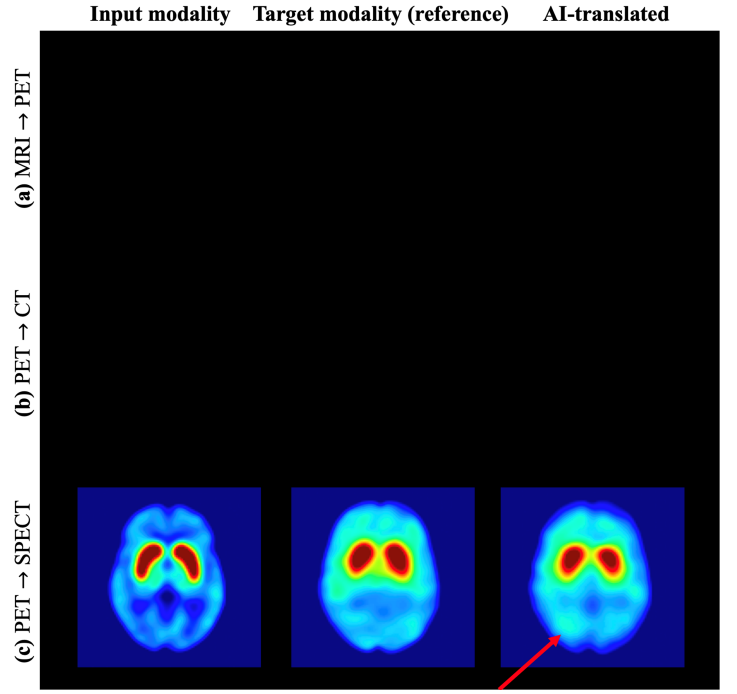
Examples of hallucinations in AI-driven cross-modality image translation. (a) MRI-PET translation (please refer to Fig. 1 in (30)). While visually realistic, the AI-generated PET image exhibits falsely increased glucose uptake in the temporoparietal lobe, which could potentially lead to misdiagnosis of Alzheimer’s disease. (b) PET-CT translation (please refer to Fig. 7 in (3)). (c) PET-SPECT translation (reprinted from (32), licensed under CC BY 4.0). Red arrows highlight AI-induced hallucinations.
